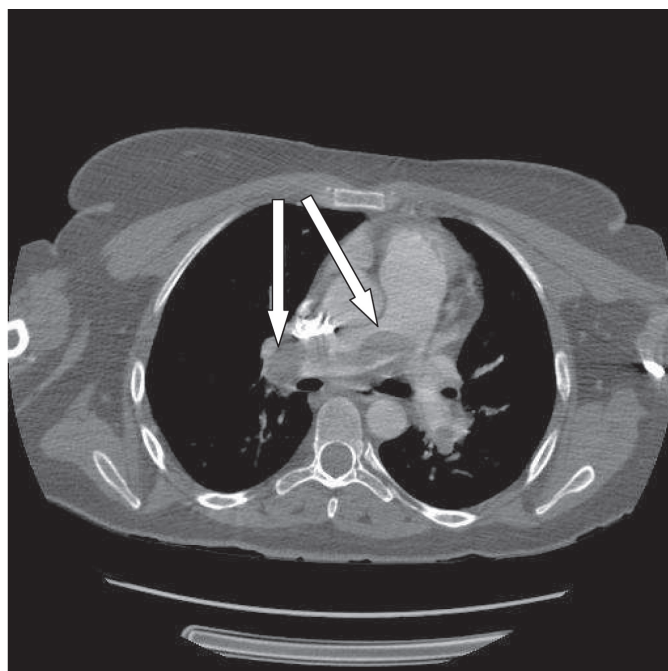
Computed tomography scan image demonstrating bilateral large central pulmonary embolism (arrows).
